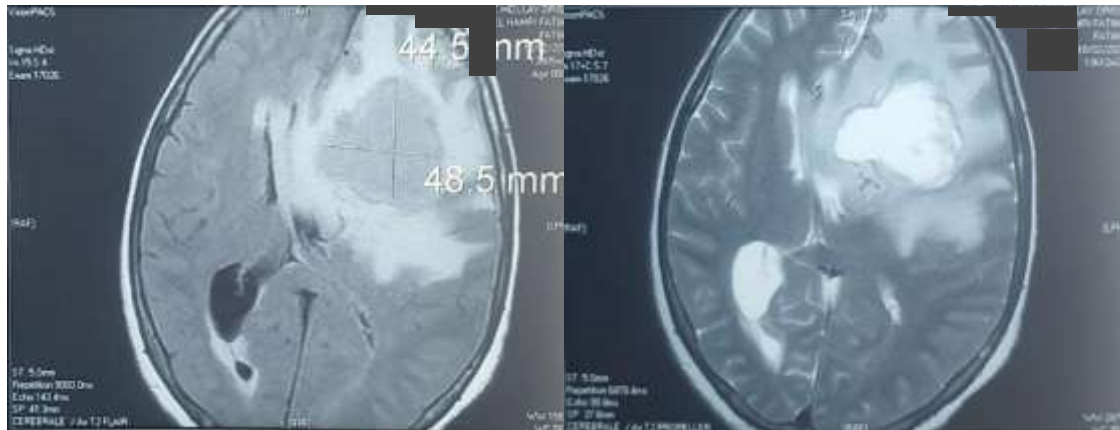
A cerebral Magnetic Resonance Imaging (MRI) revealed a left frontal tumor process 50 mm in diameter enhanced peripherally after injection of contrast product, necrotic and surrounded by significant cerebral edema determining a mass effect on the median structures with signs of engagement under falcorie.
